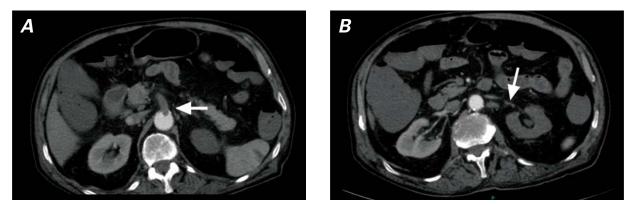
Computed tomograms (axial views) show A) segmental obstruction of the superior mesenteric artery (arrow) and B) obstruction of the left renal artery (arrow).
